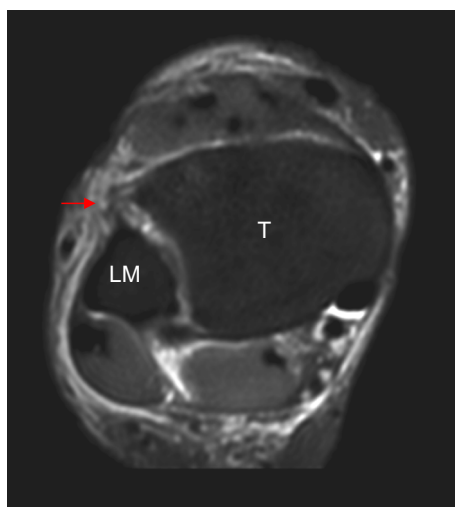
MRI. Axial MRI image showing a complete tear of the anterior tibiofibular ligament (*red arrow*). *LM* lateral malleolus, *T* tibia
